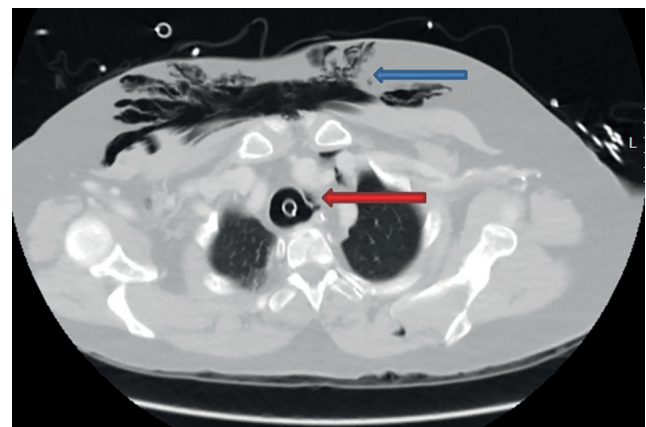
CT-chest of our patient, which showed subcutaneous emphysema (blue arrow) and a significant pneumomediastinum with a left lateral wall tracheal lesion of about three centimetres above the carina (red arrow), near the cuff which was substantially inflated.
